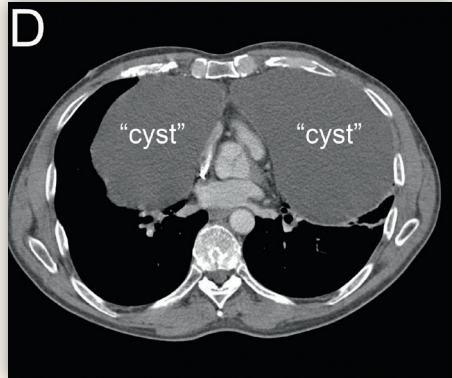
Computed tomography showing a large cyst in the anterior mediastinum encasing the heart with compression of both lungs (transverse view at the level of the aortic valve).
